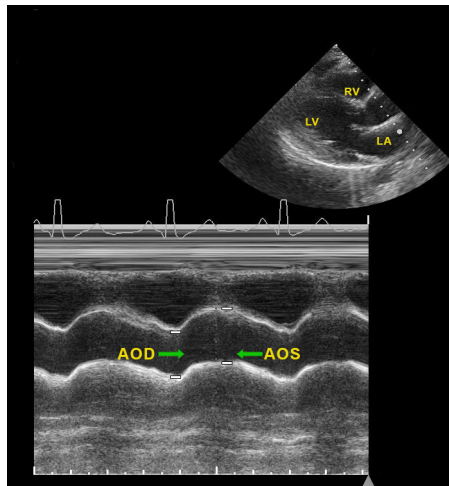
Systolic and diastolic diameter measurements of the ascending aorta via M-mode echocardiography. AOD, aortic diastolic diameter; AOS, aortic systolic diameter; LA, left atrium; LV, left ventricle; RV, right ventricle.
